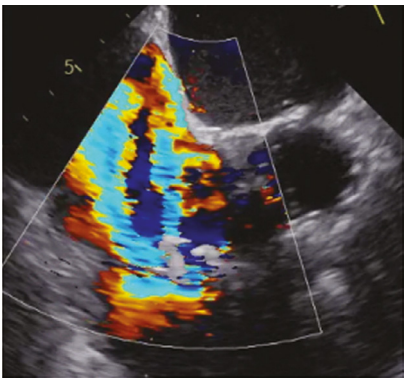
Baseline echocardiography, showing two PASCAL Ace implants and residual significant TR.
